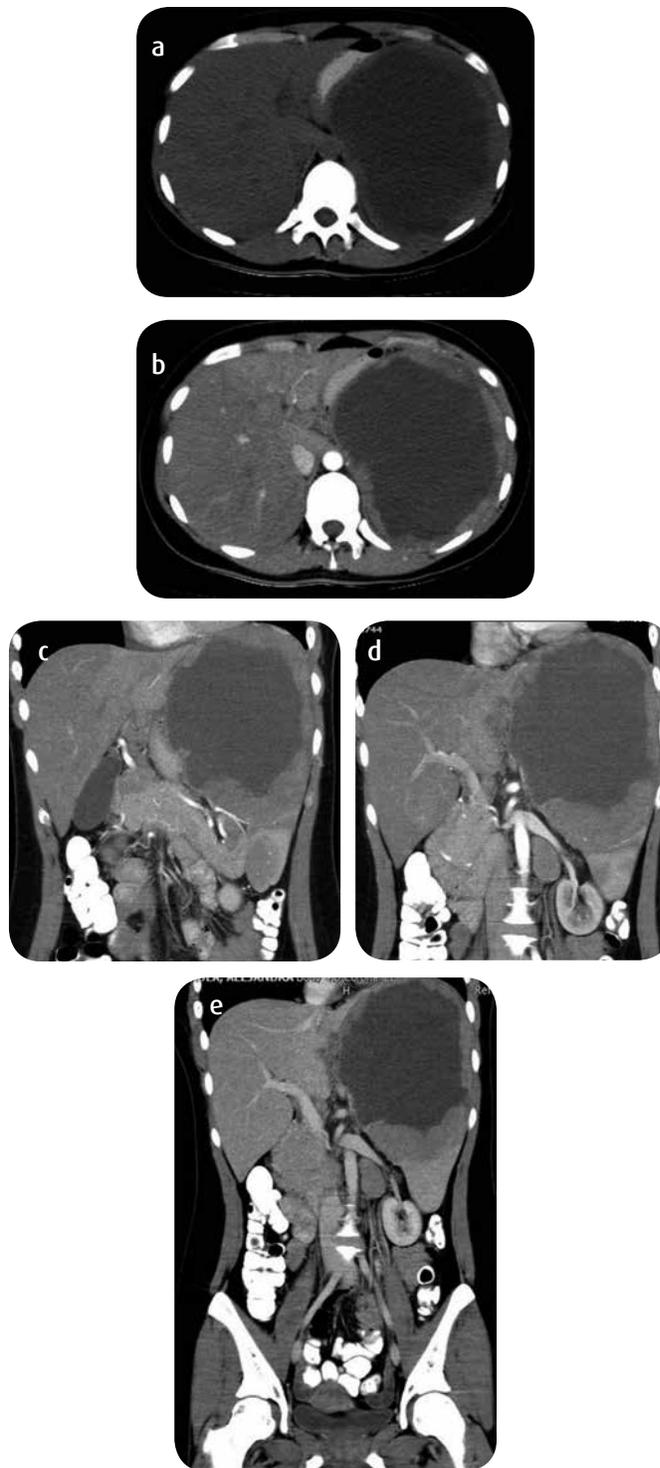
Chronic splenic rupture hematoma in a patient with NHL. a) Simple abdominal CT scan, axial cut, showing a splenic intraparenchymal collection, low signal, well defined borders, with thick and irregular wall, occupying practically the whole of the spleen, bulging its contour. In the images after the contrast medium, arterial phase, b) axial and c and d) coronal, there is absence of central enhancement with slight enhancement of the wall. e) In the portal phase there is still no enhancement of the contrast medium by the lesion. Note that the preserved splenic parenchyma in the lower pole has a normal behavior in the different phases after administration of the intravenous contrast medium.
